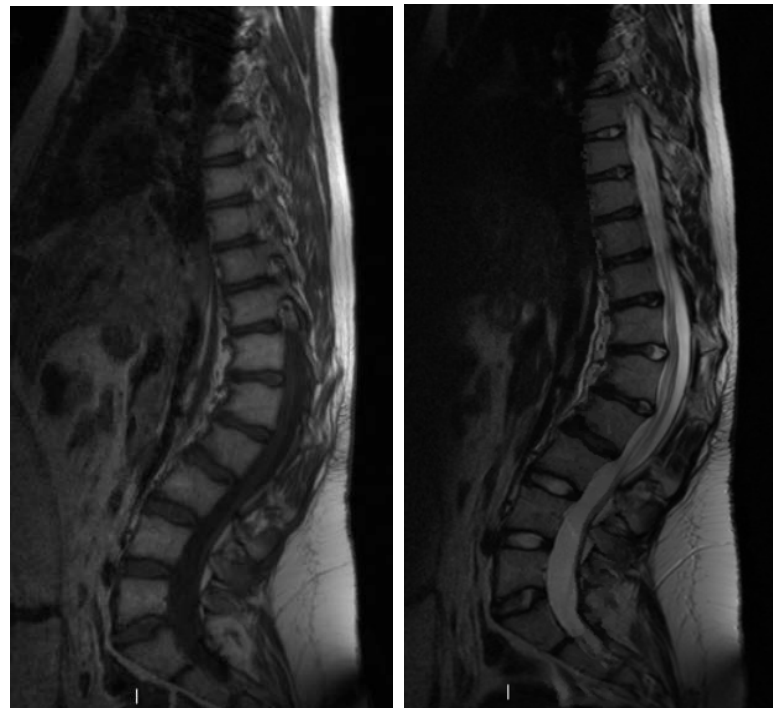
Sagittal T1 (a) and T2 (b) weighted magnetic resonance images of the thoracic and lumbosacral spine of a 14-year-old boy with Marfan syndrome showing kyphosis and dural ectasia caudally.
